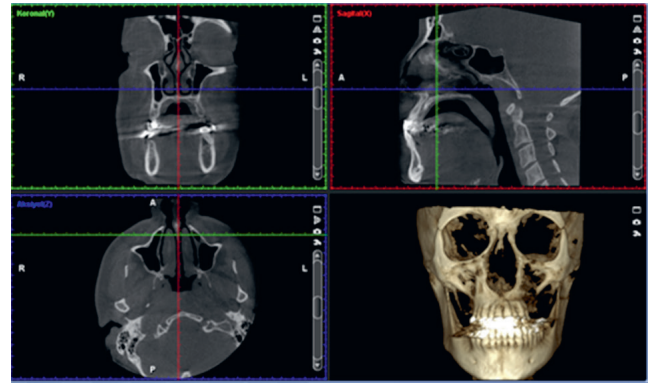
Display of structures – cone-beam computed tomography (CBCT) in sagittal, axial and coronal planes and 3D reformatted image
